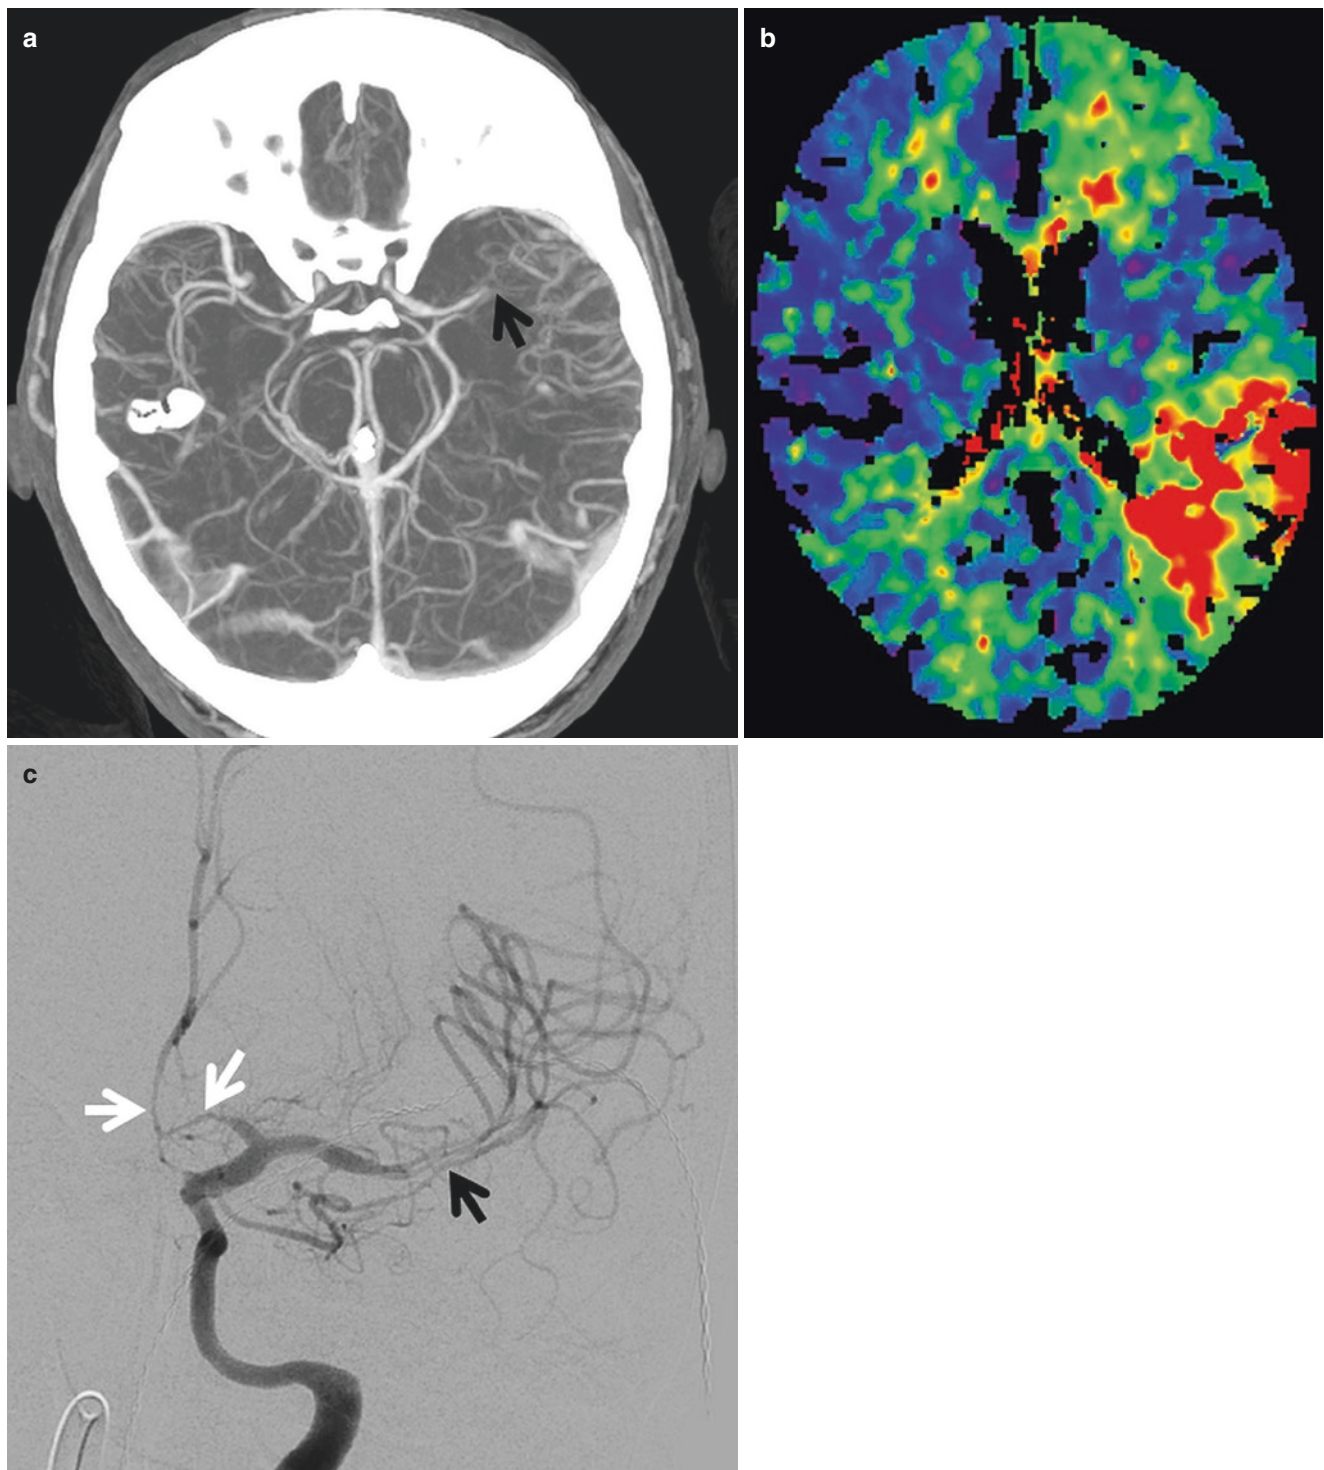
Vasospasm and delayed cerebral ischemia. Patient with SAH developed progressive right-sided weakness and elevated velocity on the TCD. (a) Axial CTA shows diffuse vasospasm, most severe at the distal left M1 segment (*arrow*). (b) CT perfusion demonstrates
